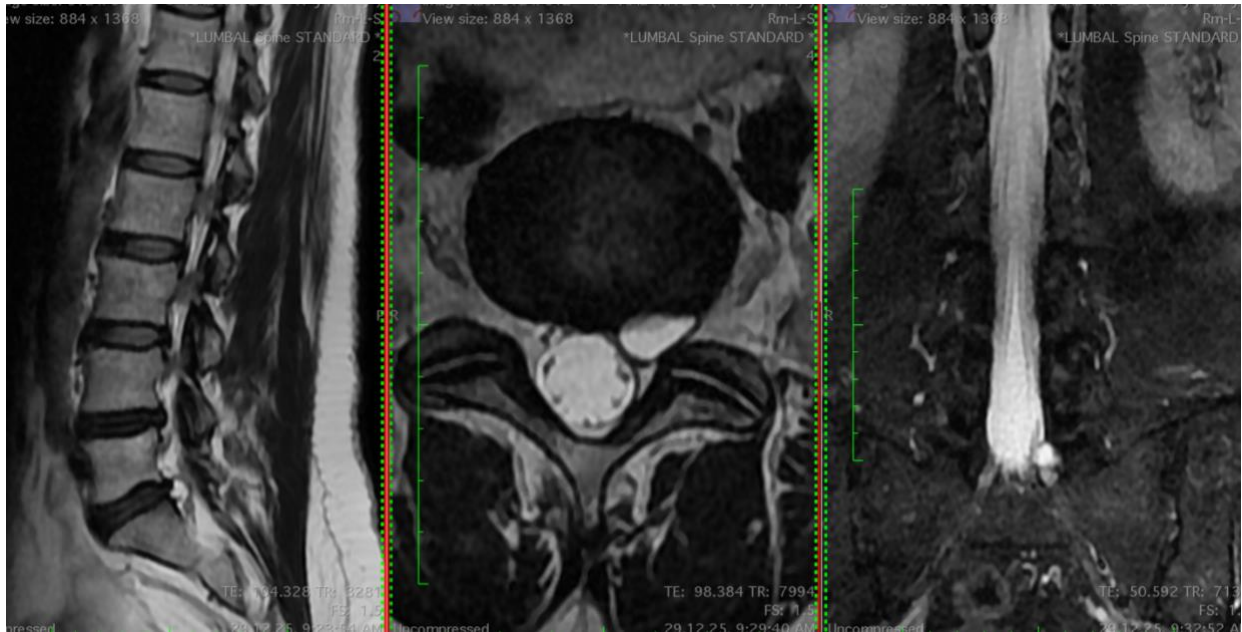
MRI of the lumbar spine demonstrated a well-circumscribed cystic lesion at the L5–S1 level
